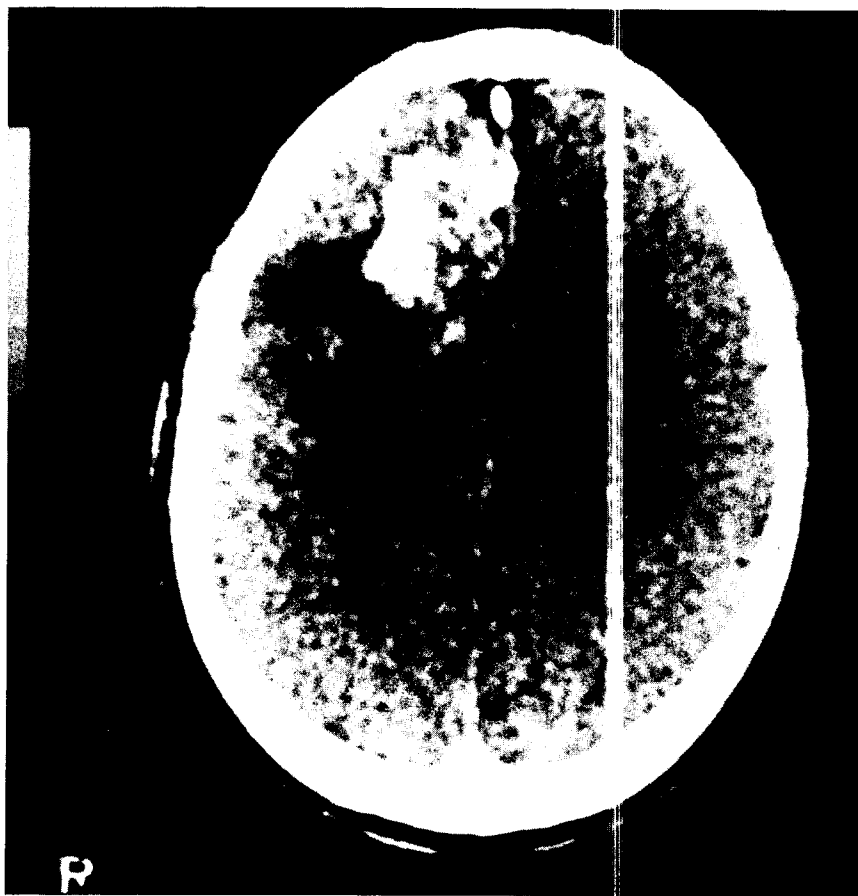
CT scan showing large area of infarction resulting from middle cerebral artery occlusion.
